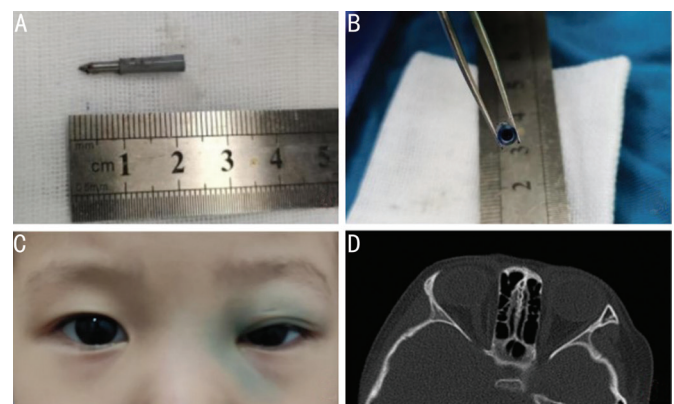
Intraoperative and postoperative pictures A: Intraoperative remove foreign bodies to neutral pen lead head end, measuring length is 22 mm; B: Wet blue ink cartridge inside is still visible; C: Appearance photo 1d after operation, the left eyelid was slightly swollen, and the range of periorbital "bruising" was the same as that before operation; D: Postoperative orbital CT showed no foreign body in the orbit. CT: Computed tomography.
